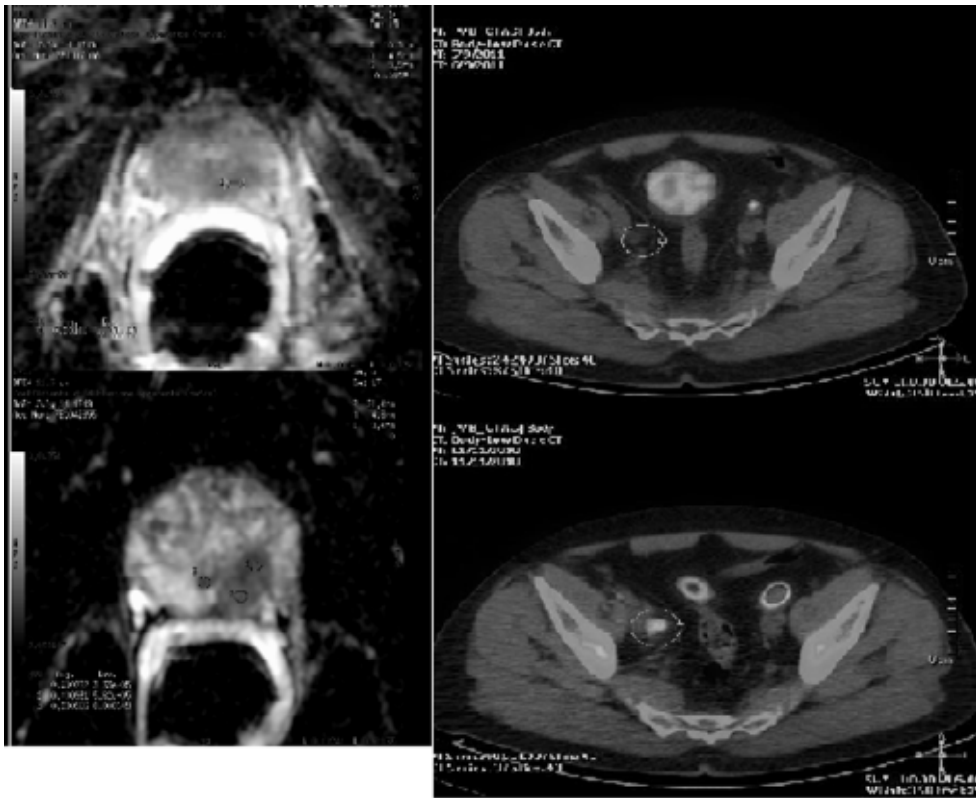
Clinical Case: iPSA 121 ng/mL, GS 8 (5 + 3), staging cT3b cN1 M0, MRI and CT-PET before (below) and after (above) RT treatment.
